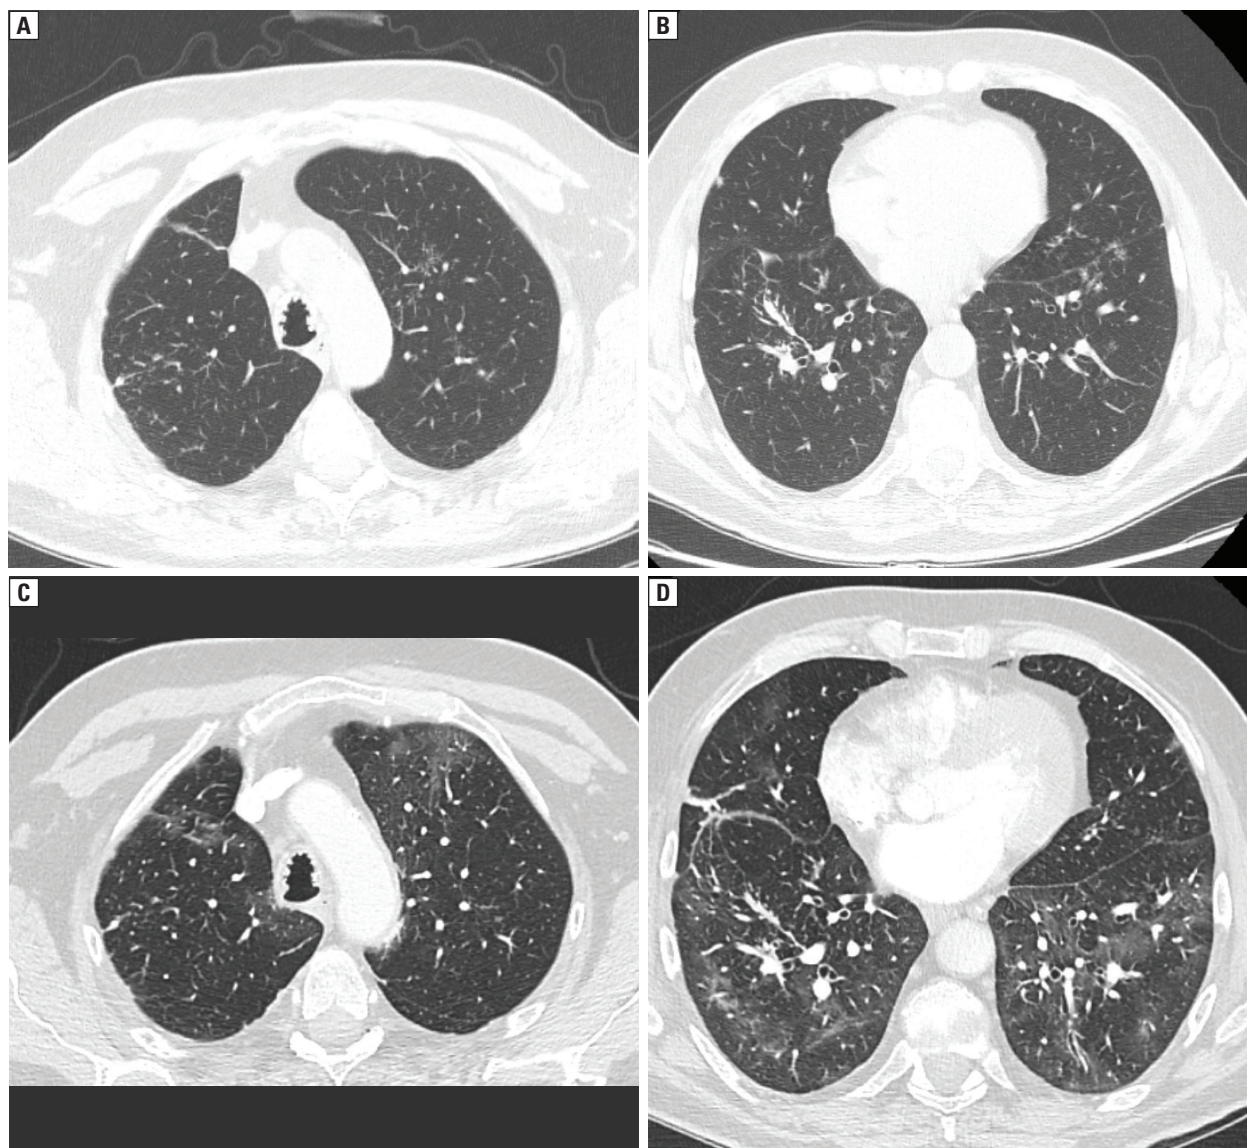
A, B. Axial computed tomography (CT) scans before SARS-CoV-2 infection, lung window. CT images show ill-defined nodules with characteristic perilymphatic distribution. C, D. Axial CT scans during SARS-CoV-2 infection, lung window. Comparing to the previous examination, CT images show the presence of diffuse ground-glass opacities
